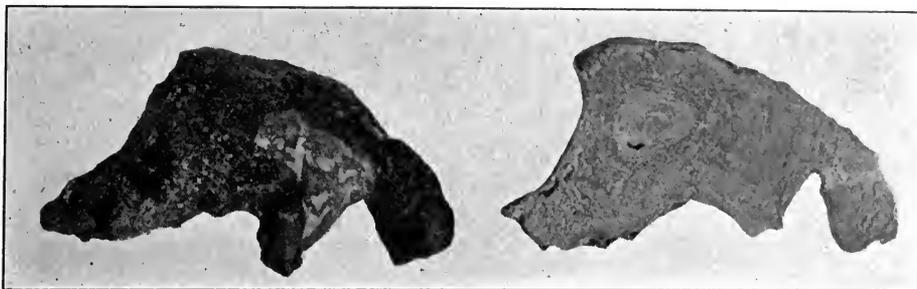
RENAL CALCULUS. Weight, 21.742 grams. Composition, center—oxalate of lime; periphery—earthy phosphates. X-ray by the author shown in preceding figure. (Case of Dr. Ellsworth Eliot, Jr.)
